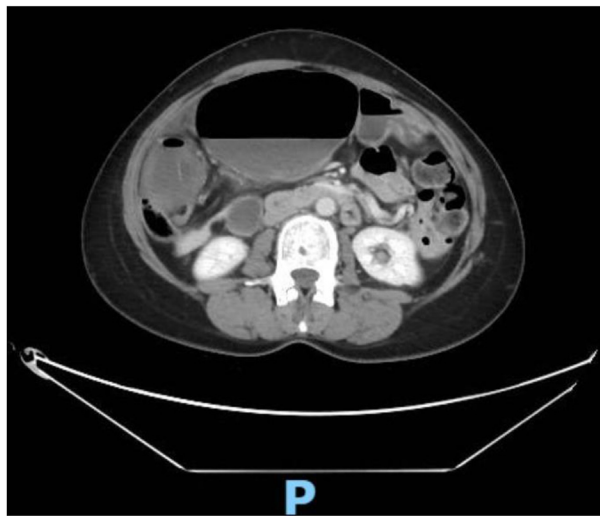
Abdominal CT scan of dilated cecum. Markedly dilated cecum with prominent air fluid levels and swirling of mesenteric vessels.
